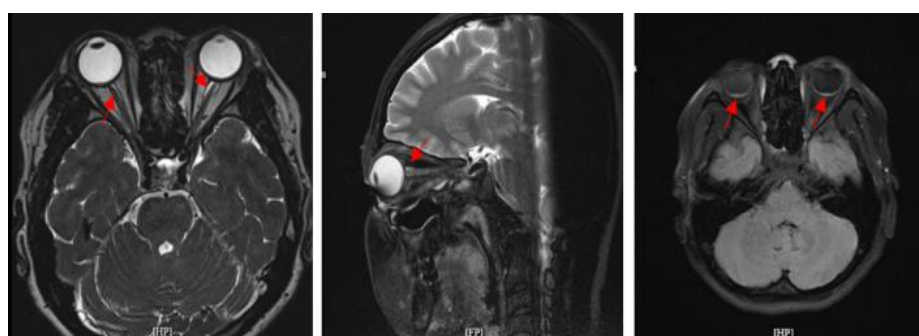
Head MRI T2 Weighted with orbital focus showed optic nerve sheath distention. A head MRI T1 Weighted with orbital focus showed a hyperintense lesion at the macula.
